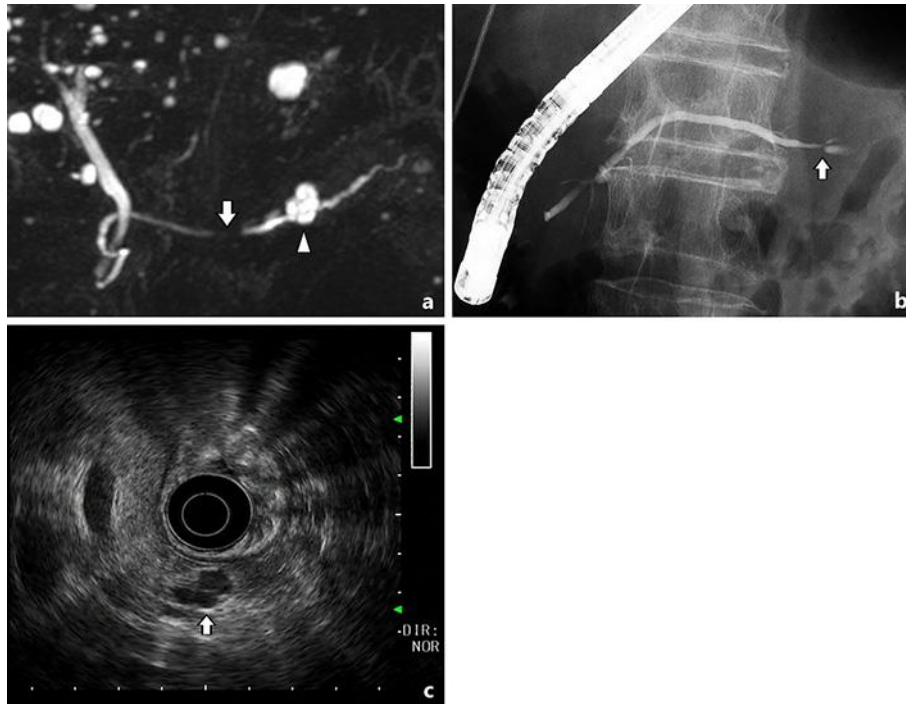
a Magnetic resonance pancreatography shows stenosis of the main pancreatic duct (arrowhead) at the pancreatic body and dilatation of the distal side of the main pancreatic duct. A multilocular cystic lesion seems to communicate with the main pancreatic duct (arrow). b Endoscopic retrograde pancreatography shows stenosis of the main pancreatic duct (arrow) at the pancreatic body. c Endoscopic ultrasonography shows a 15-mm multilocular cystic lesion (arrow) with septal structures at the pancreatic body, whereas an intramural nodule or mass shadow was not found.
